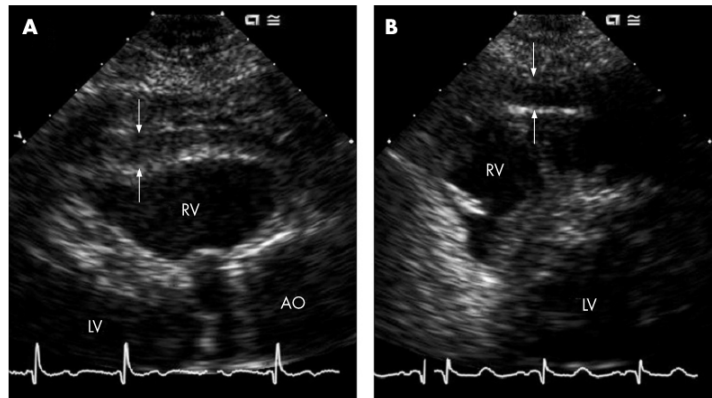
Echocardiographic measurement of epicardial adipose tissue (EAT). (A) Parasternal long-axis view; (B) parasternal short-axis view at the mitral valve level. AO, aorta; LV, left ventricle; RV, right ventricle. Anterior echo-lucent space between the linear echo-dense parietal pericardium and the epicardium was considered to be EAT (arrows). Mediastinal fat, seen as an echo-lucent area located above the parietal pericardium, was not included in the EAT measurement.
